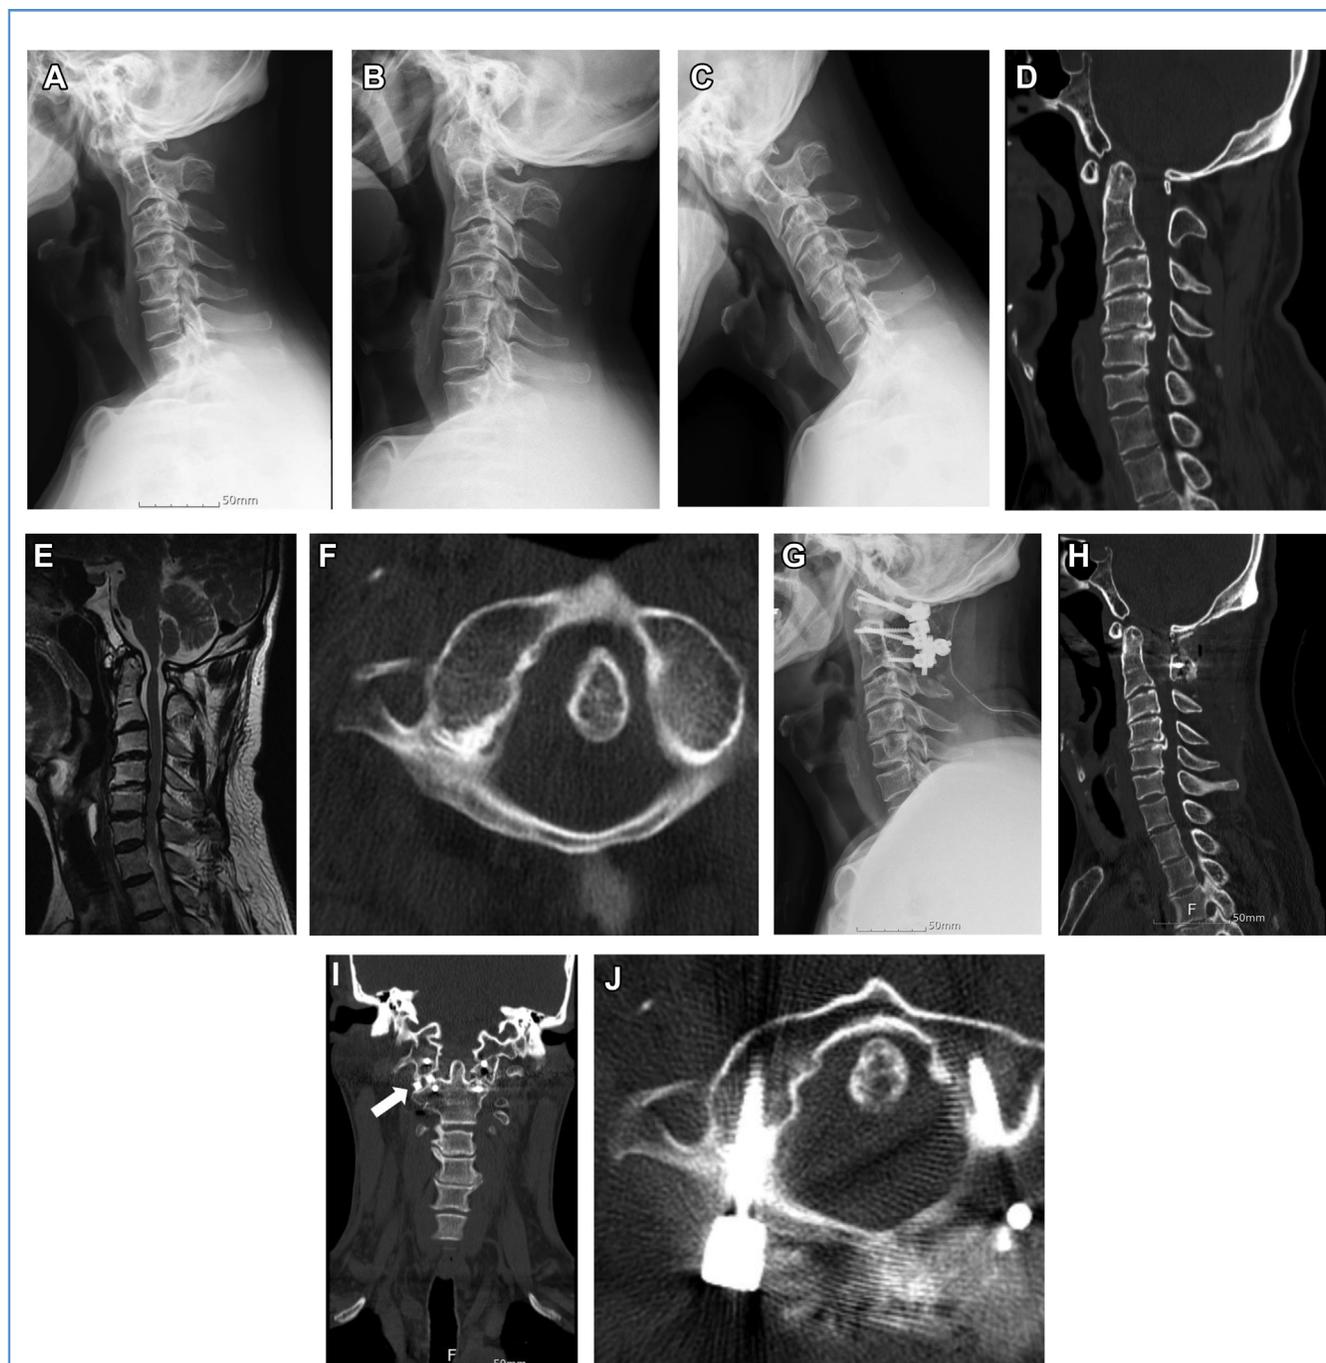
Preoperative and postoperative images showing a 54-year-old patient with vertical atlantoaxial dislocation. (A, B, C) Lateral and dynamic cervical radiograph. (D) computed tomography (CT) image showing vertical atlantoaxial dislocation combined with horizontal atlantoaxial dislocation. (E) Sagittal T2-weighted magnetic resonance image showing spinal cord compression by the posterior arch of the atlas and the dense of the axis. (F) Axial CT image showing horizontal atlantoaxial dislocation. (G)
